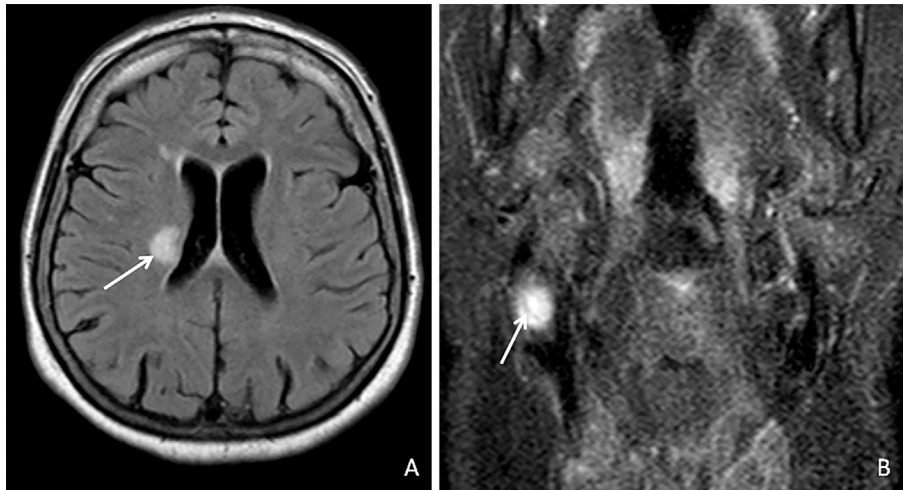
A: Magnetic resonance imaging (MRI) of the brain using the FLAIR technique which shows an acute ischemic lesion located in the right periventricular region (arrow). B: MRI of the neck using the STIR technique which shows a hyperintense signal on the bifurcation of the right common carotid artery (arrow).
